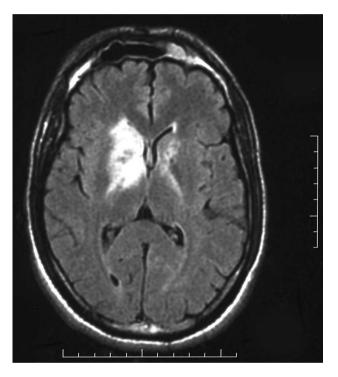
FLAIR sequence MRI showing a large lesion arising from the basal ganglia and deep white matter on the right side
